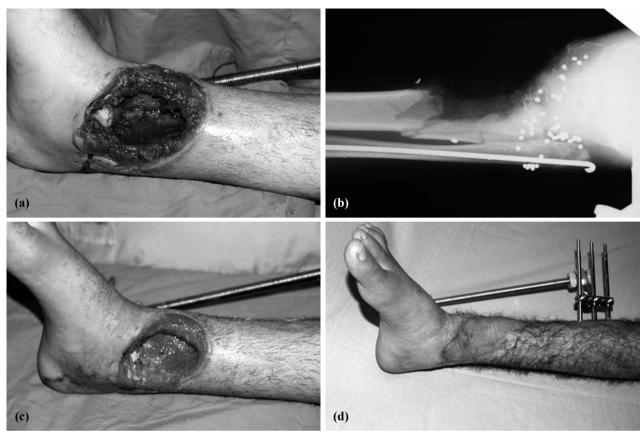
(a) Patient with a shotgun injury to the distal tibia. (b) X-ray showing the debrided distal tibia and pellets around the ankle joint. (c) Condition of the wound after vacuum-assisted closure treatment. (d) Postoperative period after the free gracilis muscle transfer.
